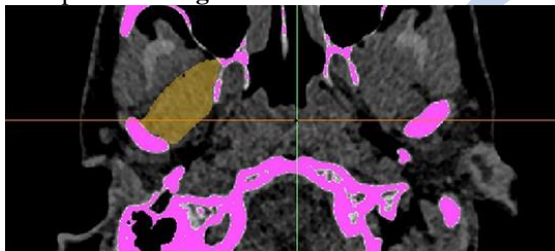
Axial cut of CT scan showing segmentation of lateral pterygoid muscle.
